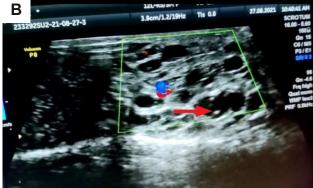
HRUS Scrotum of 24 Years Male with Scrotal Pain and Fever. (A) Microfilariae in Scrotum (red arrow). (B) Colour Doppler Imaging Showing Filarial Dance Sign (yellow arrow).
